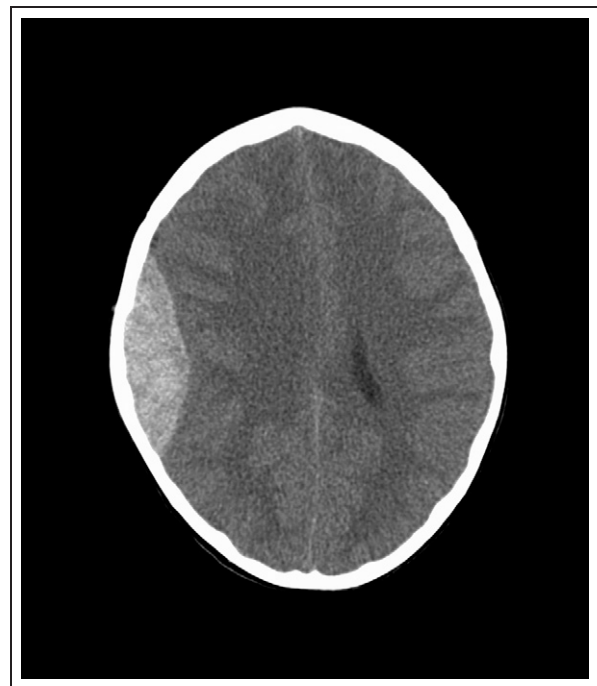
This CT scan demonstrates a right epidural hematoma with typical lens shape. The mass effect has caused effacement of the lateral ventricle and shift of the midline to the patient's left.
